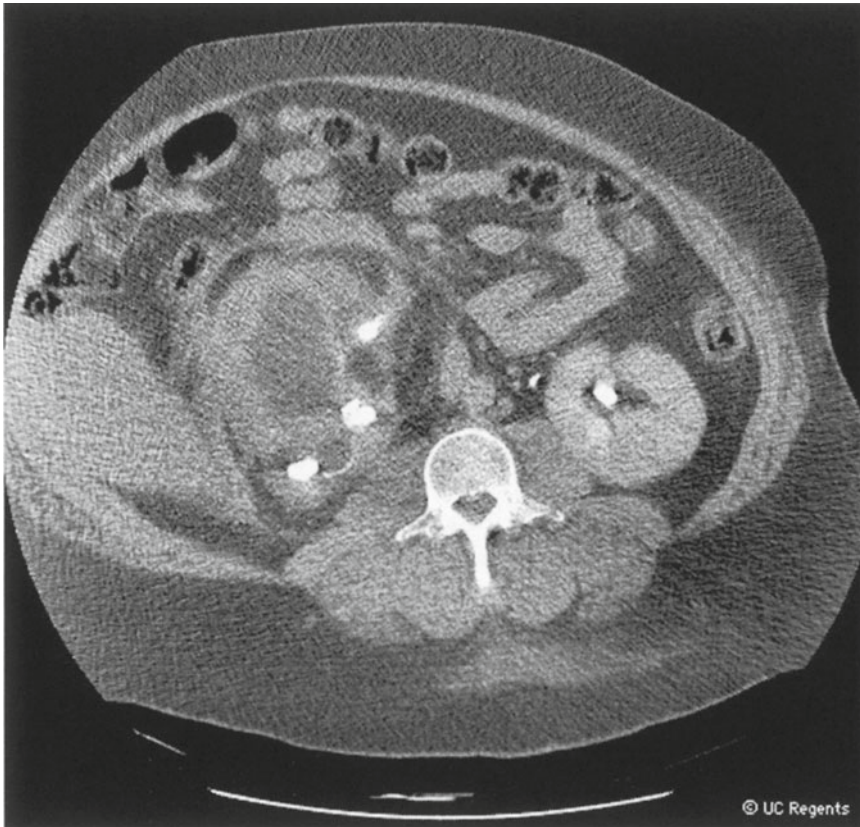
Delayed CT demonstrating right xanthogranulomatous pyelonephritis. Note the multiple calcifications as well as nearly absent renal parenchyma and evidence of inflammation within Gerota' fascia
